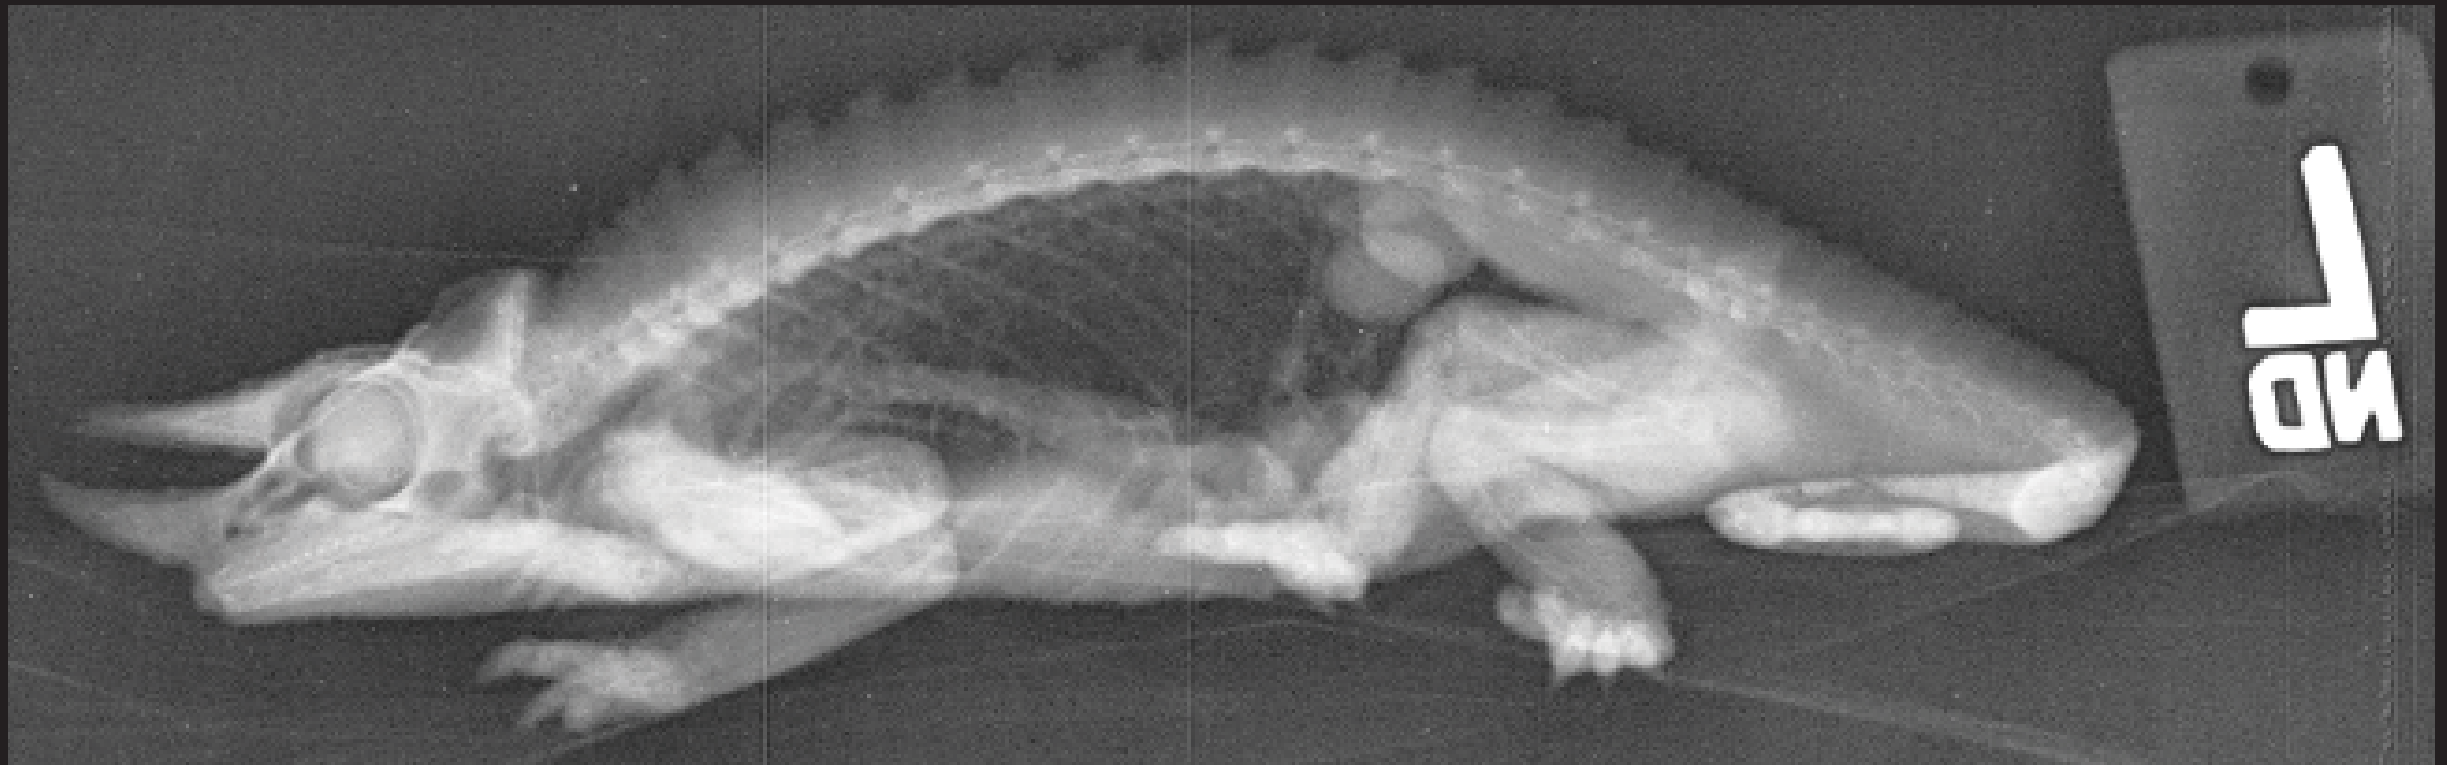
Total body radiographic image of a veiled chameleon (*Chamaeleo calypttratus*), lateral projection.
